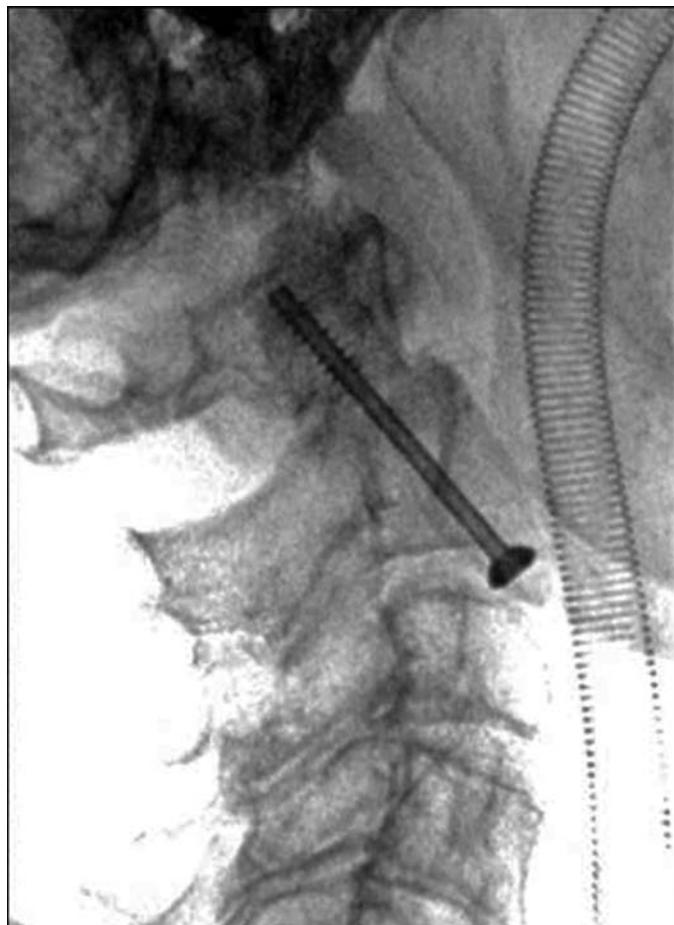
Lateral radiograph showing good fracture reduction intraoperatively.
